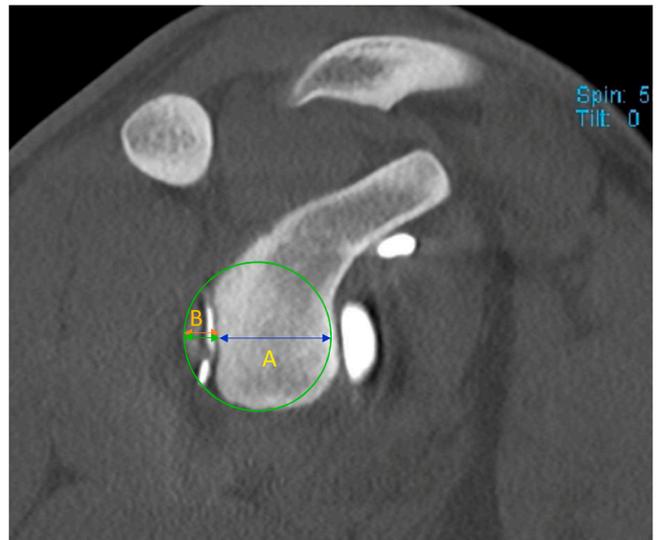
Posterior glenoid bone defect (fracture or erosion) measured on 2D CT sagittal slice as  $A/A + B$ .
